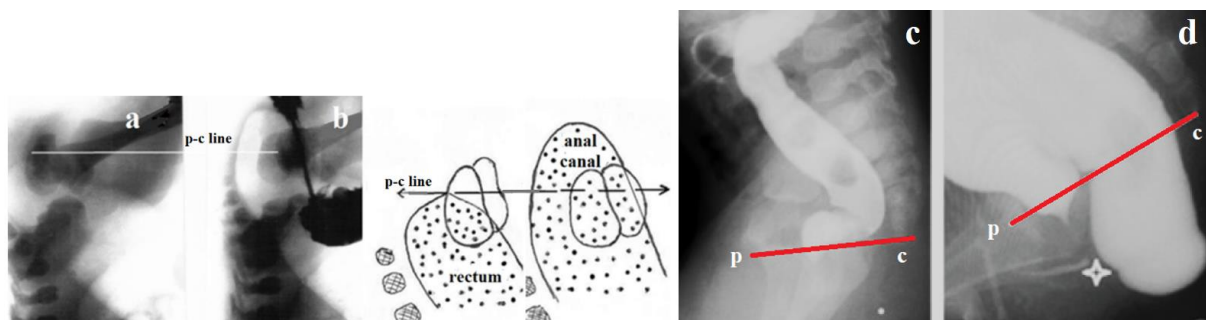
Radiographic studies of patients with urethral ectopy of the anus. (a). In a newborn without a visible fistula, the distal intestinal contour, filled with gas, is located at the level of the pubococcygeal line, i.e., on the border between the anal canal and the rectum. (b). During an unsuccessful attempt to inject contrast agent into the rectum, the anal canal opened and gas approached the perineal skin. (c-d). Radiographic studies of boys with “rectourethral fistula” performed using high rectal pressure from the article by Kraus et al [13]. (c). The authors state that the rectal sphincter is closed and not distended because of inadequate pressure. (d). With adequate pressure, the contrast agent filled the wide rectum, which contacts the urethra [13]. The distal edge of the intestine is located far from the P-C line (drawn by me), near the perineal skin.
